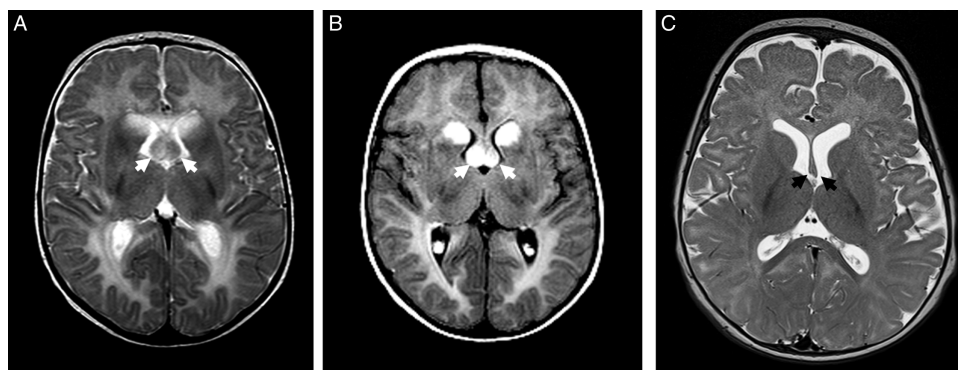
MRI-brain: axial-T2 (a) and post-gadolinium FLAIR (b) sequences demonstrate diffuse white matter hyperintensity with swollen caudate nuclei and anterior forniceal columns bilaterally (cherry-like appearance) and avid enhancement (white arrows). Other findings included periventricular T1-hyperintensity rim, T2-hyperintensities in thalami, midbrain, and dentate nuclei. Normal MRI (c) at similar age shows normal forniceal appearance (black arrows).
